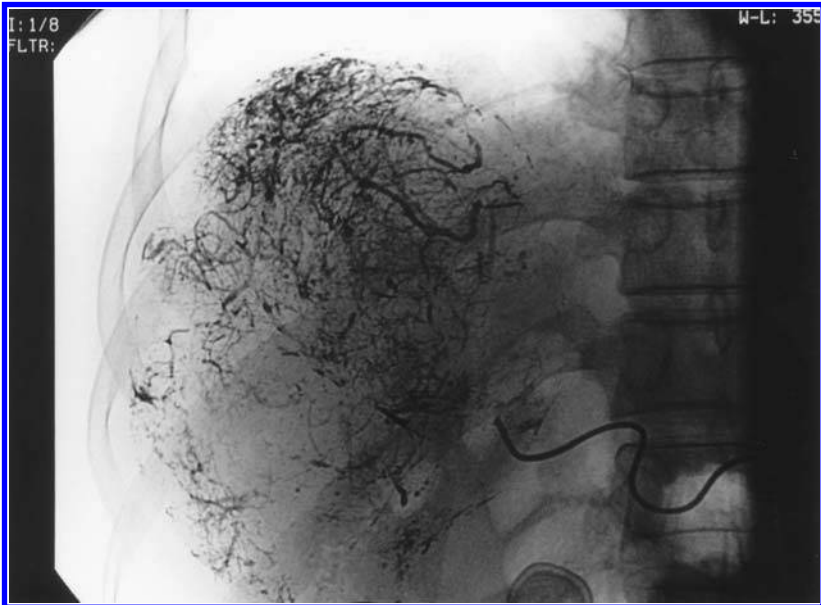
Postembolization with ethiodol, ivalon, cisplatin, doxorubicin, and mitomycin. The tumor vascular bed has been saturated with the embolic medium and is seen on the radiograph image because of the density of ethiodol.
